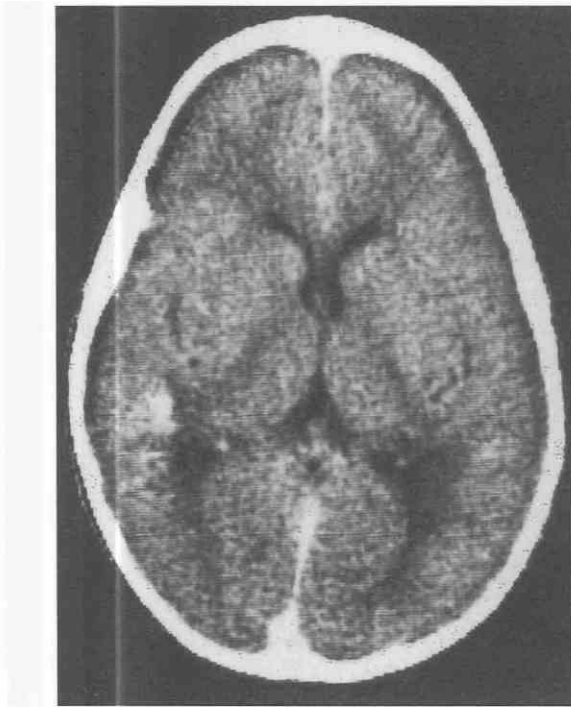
CT scan shows calcification with leukoencephalopathy (mineralizing microangiopathy). The patient is a 7-year-old girl who, 1 year previously, had received 55 Gy to the posterior fossa for a cerebellar astrocytoma. At the time of the scan, she was asymptomatic. The heavily calcified focus in the right parietotemporal region is typically situated at the interface between the cortex and white matter; the latter is abnormally lucent just medial to the calcification. Similar subtle changes are mirrored in the opposite hemisphere.
